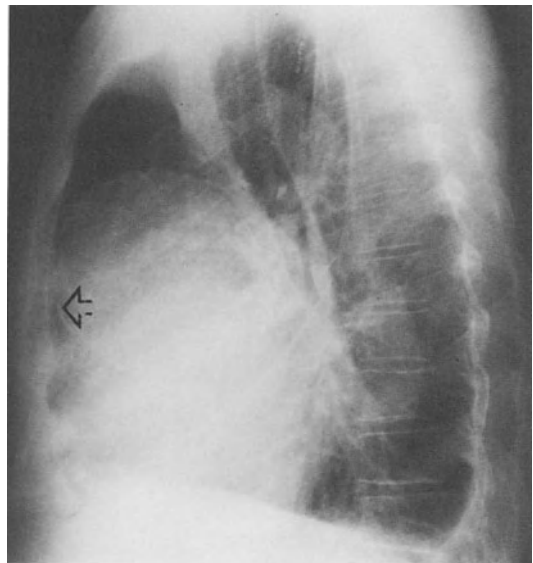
X-ray demonstrating a saccular aneurysm of the ascending aorta in Marfan syndrome. Calcification (arrow) is seen in the lateral view.
